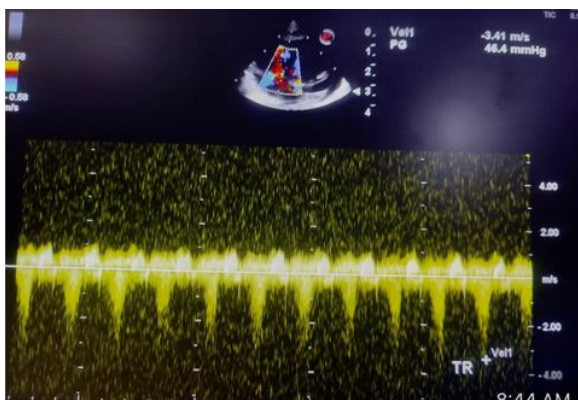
CW Doppler across Tricuspid Regurgitation jet shows a peak velocity of 3.6 m/sec (gradient 52 mm hg). The estimated right ventricular systolic pressure/ pulmonary artery pressure was (52+ 15) 67 mm hg, suggestive of severe pulmonary hypertension.
